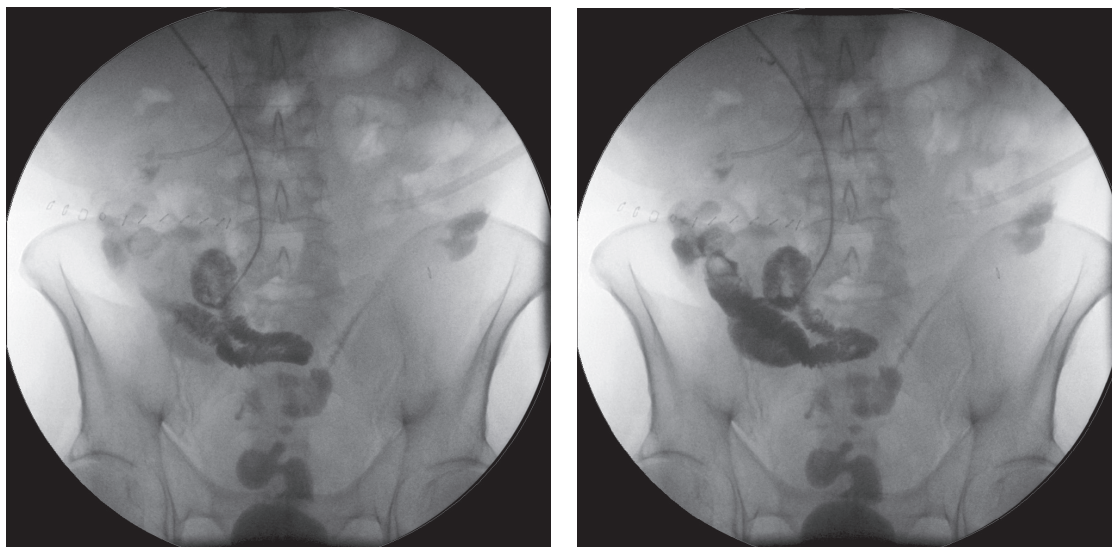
X-ray of a fistulogram.
